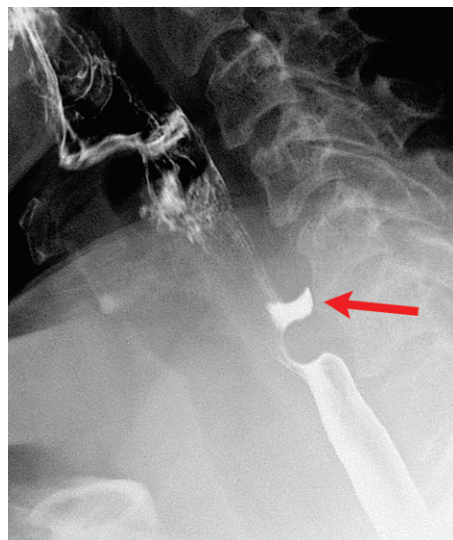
Pseudo-Zenker diverticulum in a 69-year-old woman. Lateral radiograph of the pharynx after swallowing shows an outpouching in the location of the Zenker diverticula (arrow). The outpouching was not identified when the pharyngeal lumen was fully distended during the passage of the bolus (not shown).
